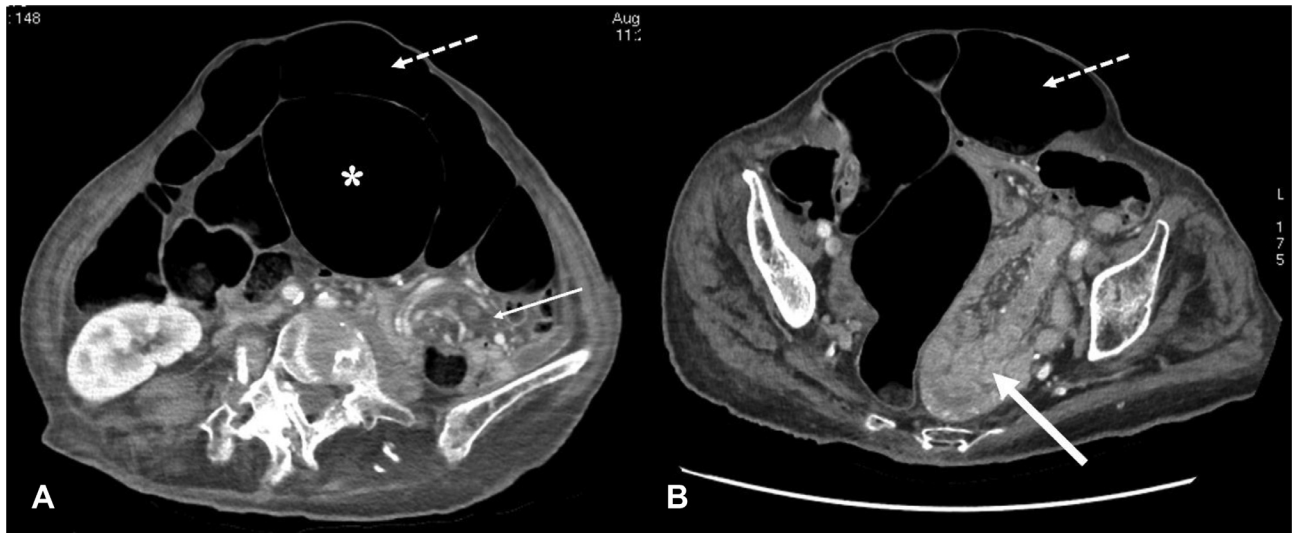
(A, B) Small bowel volvulus. Axial portal venous phase CT image (A) shows the “whirlpool sign”, pathognomonic for small bowel volvulus, seen when the bowel rotates around its mesentery thus causing the mesenteric vessels to twist (thin arrow). In this case, it is possible to see the jejunal-ileal branches of the superior mesenteric artery forming a whirl. Additionally, it is possible to see the sigmoid dilatation (asterisk) and the median laparocoele (dotted arrow). Portal venous phase image (B) showing the median laparocoele (dotted arrow) and multiple small bowel loops, localized distal to jejunal volvulus, disposing abnormally in the pelvic cavity (thick arrow).
